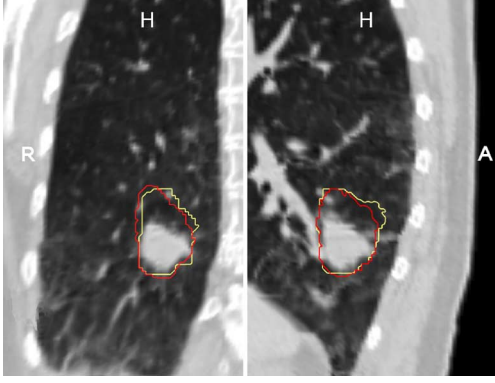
Visualization of the internal target volume (ITV) of patient 01 in a coronal (left) and sagittal (right) CT slice. The ITV was calculated from expert-defined tumor segmentations in EI, EE, ME, and MI (yellow contour) and from tumor positions predicted by the average motion model (red contour).
